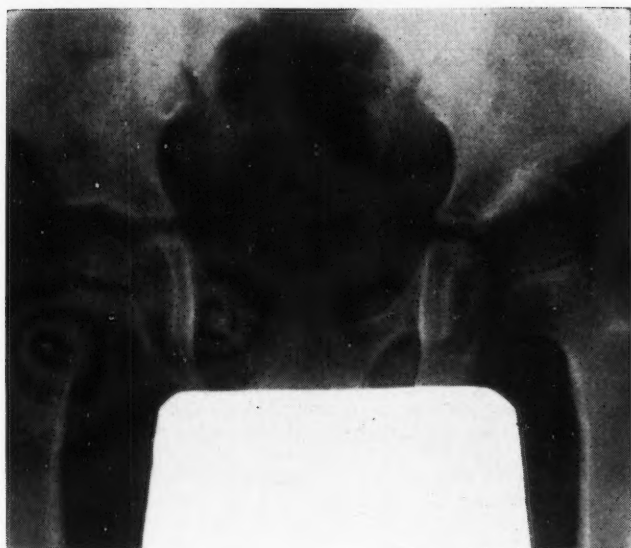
Appearance of lead shield on radiograph of child's hip.
